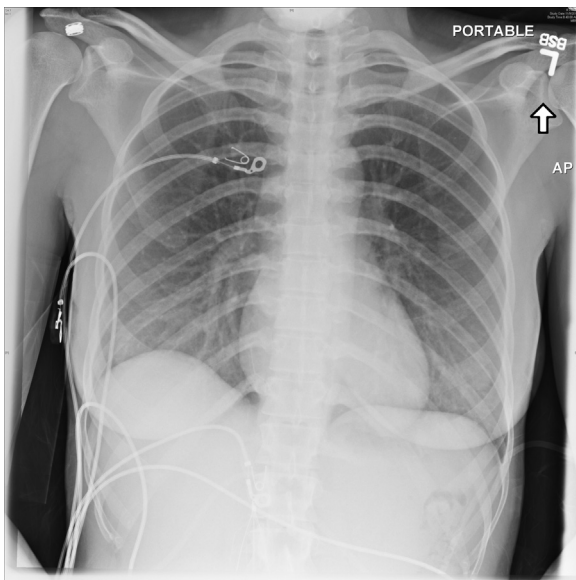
Anterior-posterior chest radiograph.
